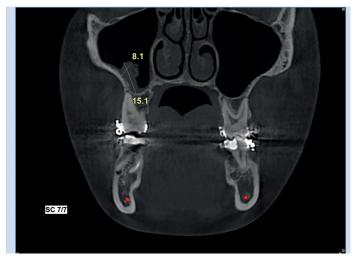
Coronal CBCT image of the fungus ball in the right maxillary sinus
